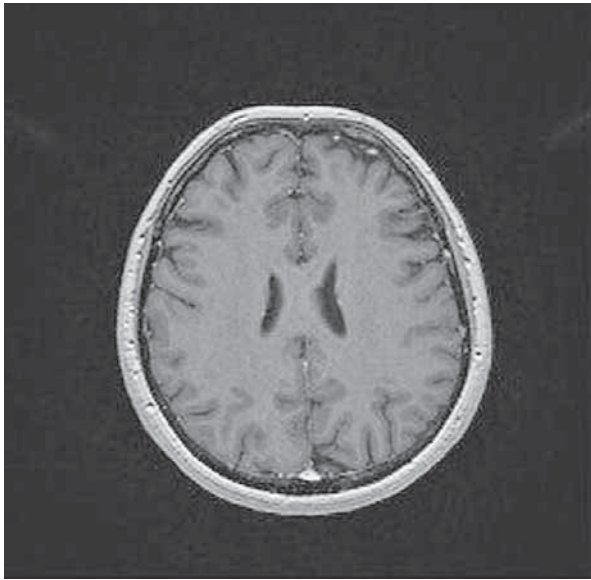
Control axial contrast enhanced T1-weighted MRI shows normal findings.
